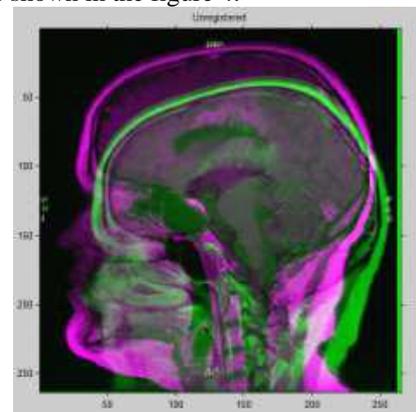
Unregistered MRI Image
